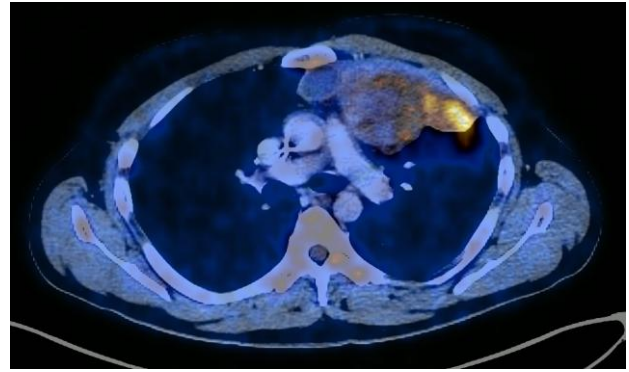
Axial 18F FDG PET CT image of increased metabolic uptake within anterior mediastinal mass.
